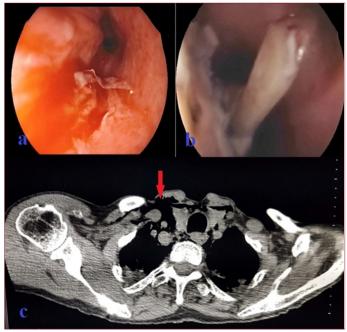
Endoscopic image of chicken bone stuck in the mucosa in the esophageal lümen and damage to the mucosa (a, b), appearance of free air secondary to perforation in the mediastinum by CT (c) (red arrow)
